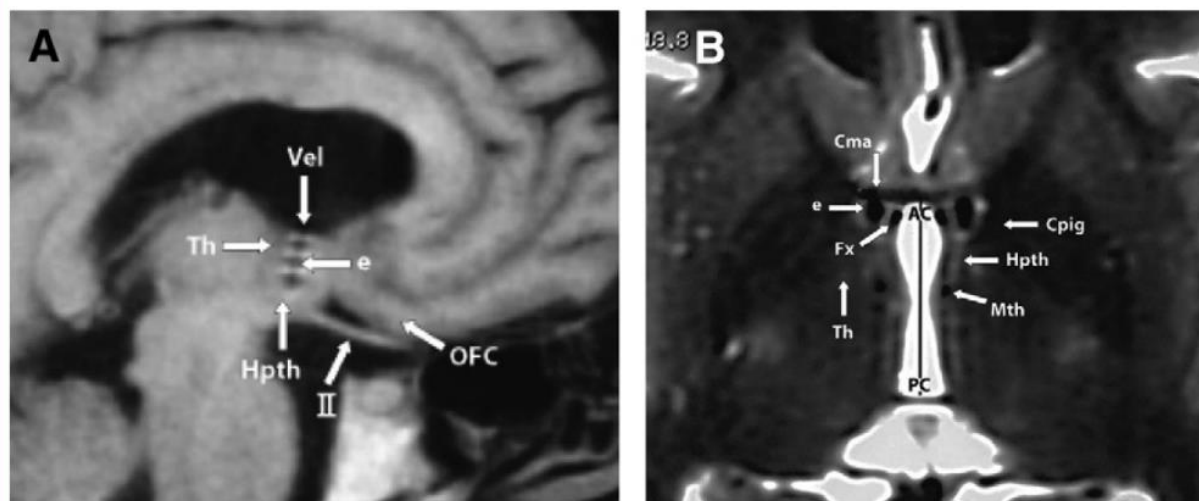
A postoperative magnetic resonance image showing electrode position. (A) Sagittal Section corresponding to 6.0 mm lateral to midsagittal plane, as for Figure 1A. (B) Axial T2 sequence at the intercommissural plane (AC-PC) level where the electrode (e) was placed, taken as reference fibers of the anterior commissure (Cma), fornix (Fx), mammillothalamic tract (Mth) and genu of internal capsule (Cpig) for direct targeting, that corresponds to Figure 1B. Hpth, hypothalamus.
